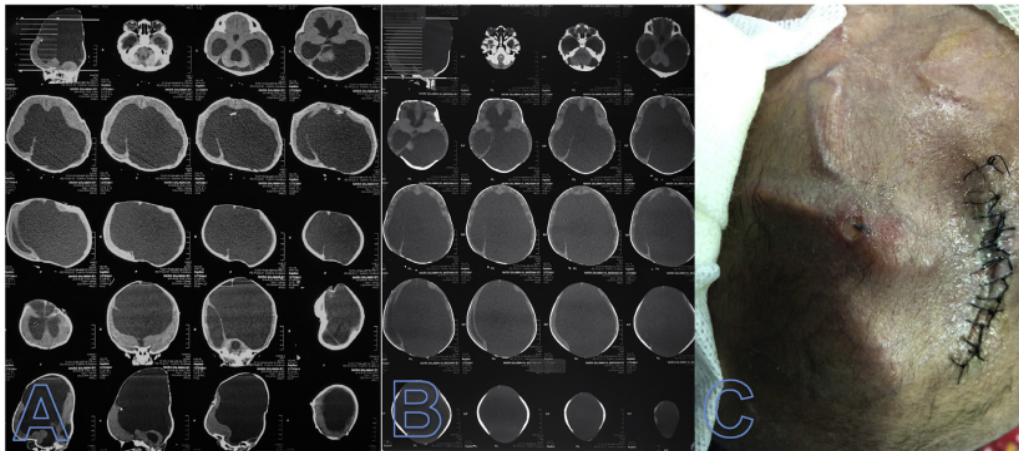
The sixth case, a 2-month-old baby with 3.2 kg of weight was admitted to the hospital complaining with exposed shunt. A and B Pre procedural CT Scan; C. Pre procedural clinical image.
